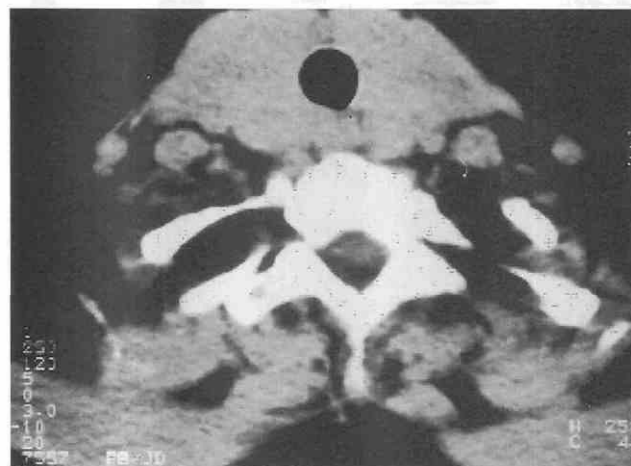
Unenhanced CT scan shows a diffusely enlarged, homogeneous thyroid gland in a patient with Hashimoto's thyroiditis. No focal masses or calcifications are noted.
